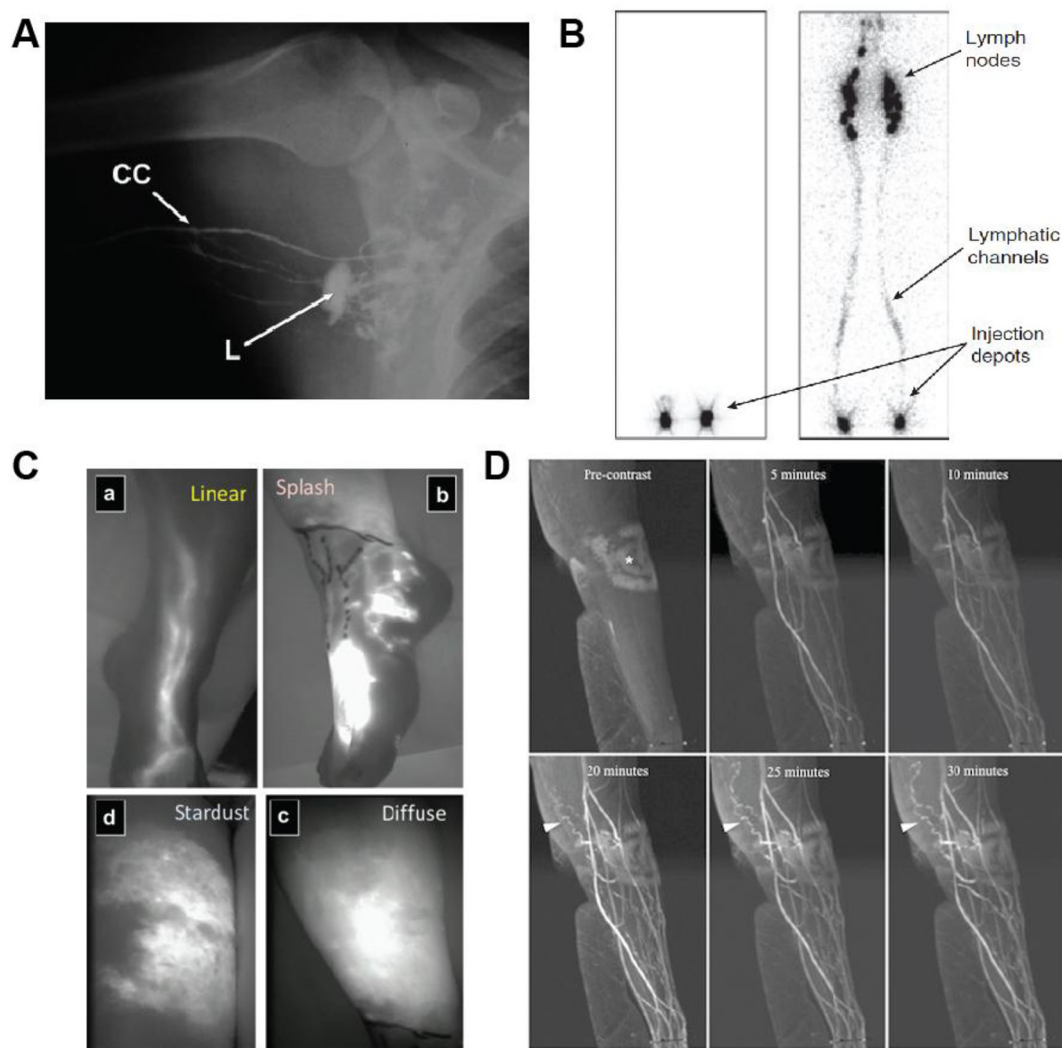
State-of-the-art clinical imaging of the lymphatic system with tracer-based techniques. (A) X-ray lymphography. Radiographic image during axillary lymph node mapping with Lipidol. In the left image, three larger afferent lymphatic collectors of the upper extremity are shown. Collectors (CC) are directed to larger, laterally-localized axillary lymph node (L). Reproduced with permission [8]. (B) Lymphoscintigraphy. Lymphoscintigrams of the legs after subcutaneous injection of radioactive tracers in the feet (foot depots marked with the arrows). Left image shows minimal lymphatic uptake in legs of patient with primary unilateral lymphedema. Right image shows the lymphatic routes and inguinal lymph nodes imaged in normal control individual. Reproduced with permission [42]. (C) NIR lymphography. Dermal backflow patterns that correlate to severity of lymphedema and lymphatic dysfunction in comparison to normal linear flow pattern (left). In extreme cases of no flow, the tracers may not extend beyond the injection site. Reprinted with permission [55]. (D) Dynamic MR lymphography with Gd-based tracer in the upper arm with lymphedema. Progressive enhancement of the lymphatic channels over time. Irregular radiating lymphatic channels are seen extending from the lateral forearm towards the medial left elbow in a characteristic irregular, beaded pattern (arrowheads). Reprinted with permission [66].
